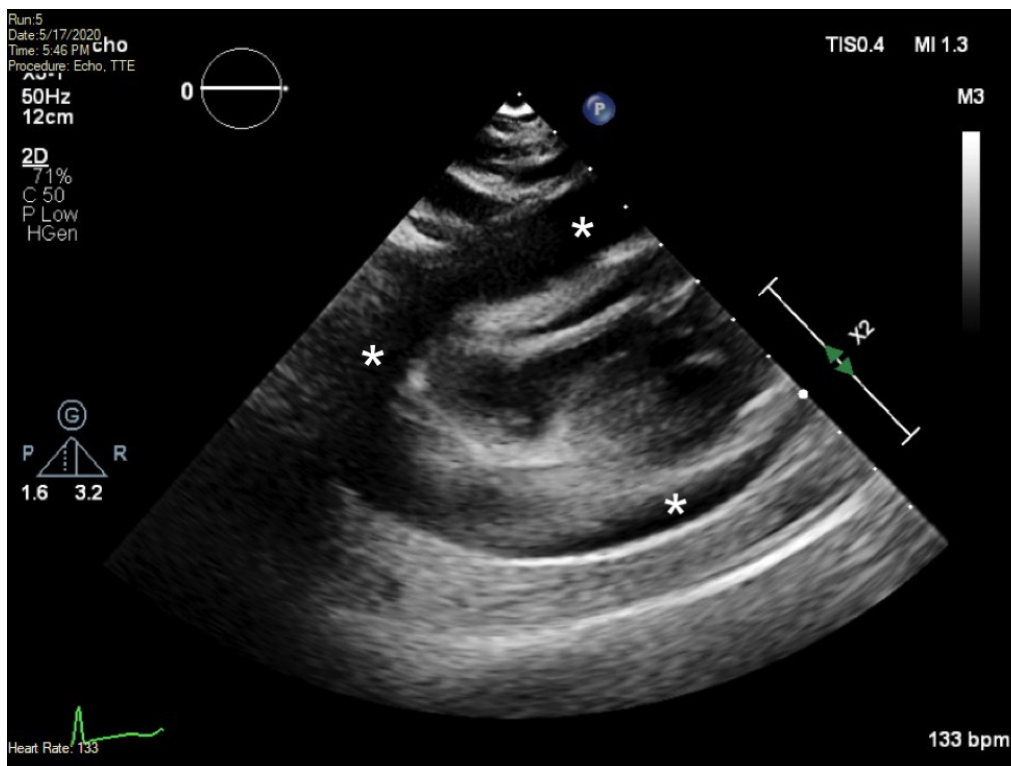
Transthoracic echocardiogram revealing moderate to large pericardial effusions marked by the asterix.
